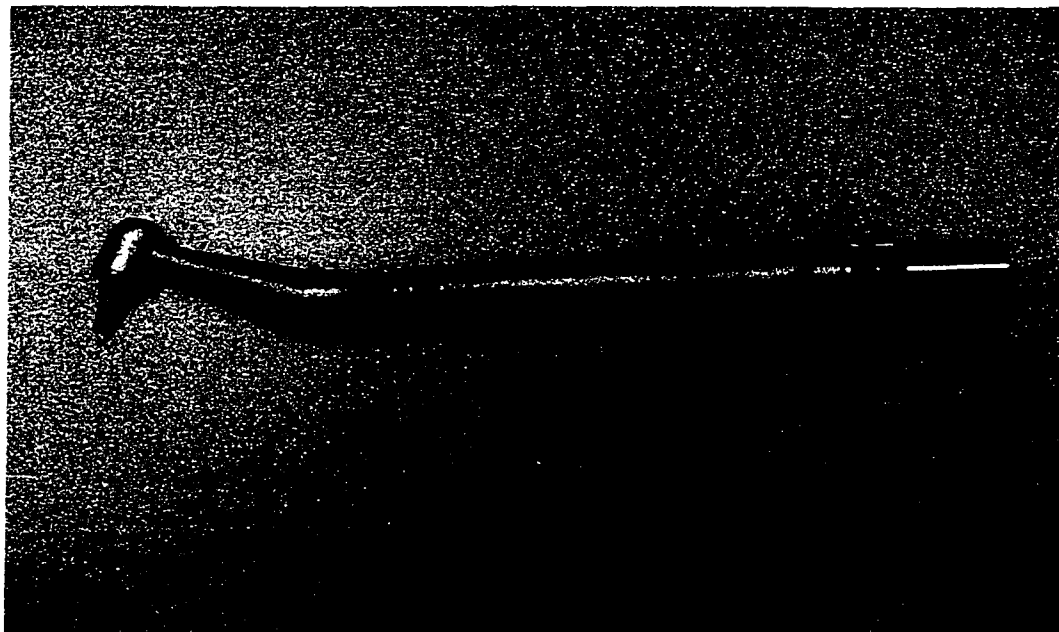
The next-generation ultrasonographic probe arising from this work.
